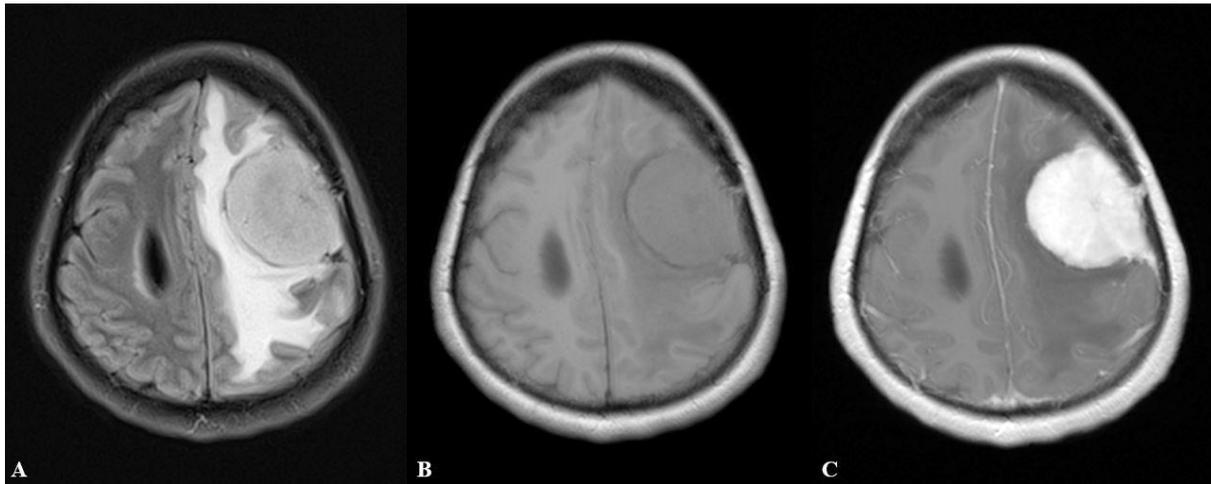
Head MRI of 42 y.o. female with atypical meningioma, axial T2-FLAIR (A), T1WI (B), and T1 post-contrast (C). There was a solid mass on left frontal convexity with significant peritumoral oedema causing slight midline shift to the right. CSF cleft sign was clearly seen on T2-FLAIR and T1WI. On T1 post contrast the mass demonstrated strong homogenous contrast enhancement and dural tail.
